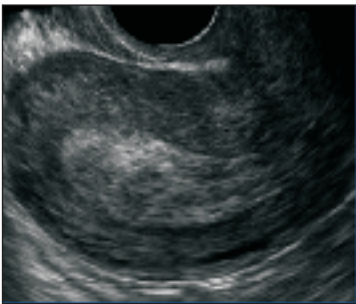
Transvaginal sonogram showing absence of a gestational sac and thickening of the endometrial lining. This thickening, visible as echodense tissue, extends into the lower uterine cavity.
